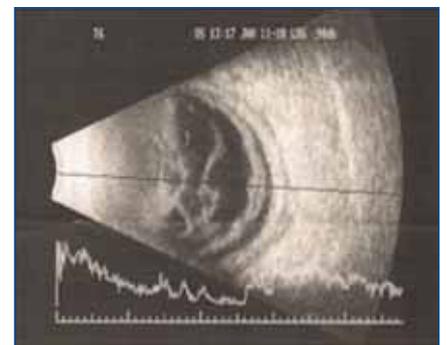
Ocular ultrasound. Vitreous infiltration in anterior area with detached choroid and retina.
